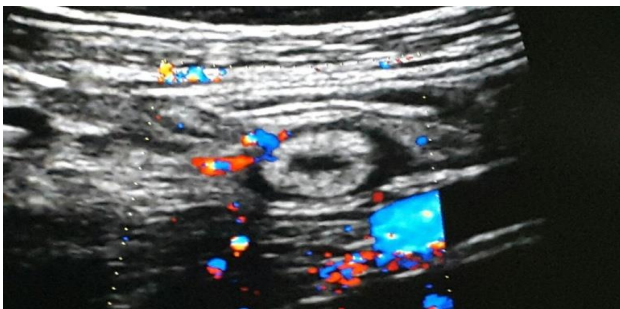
USG transverse section of appendix with Doppler effect.
